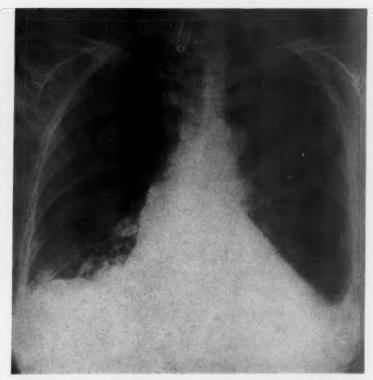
Case 14. Chest x-ray, 12/2/56. X-ray report: "Enlarged heart with hypertensive configuration . . . sclerotic aortic knob . . . lungs show increased markings of bilateral congestion and calcified nodes in the right sub-clavicular area." Pleural fluid not mentioned.
